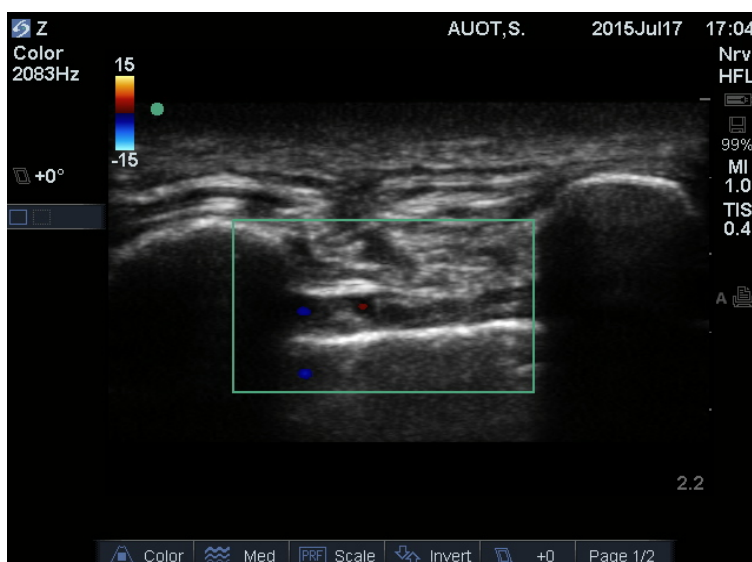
Ultrasound image of the same space, with frame indicating boundaries of colour Doppler applied, to reveal location of blood vessels before injection using out-of-plane technique.
